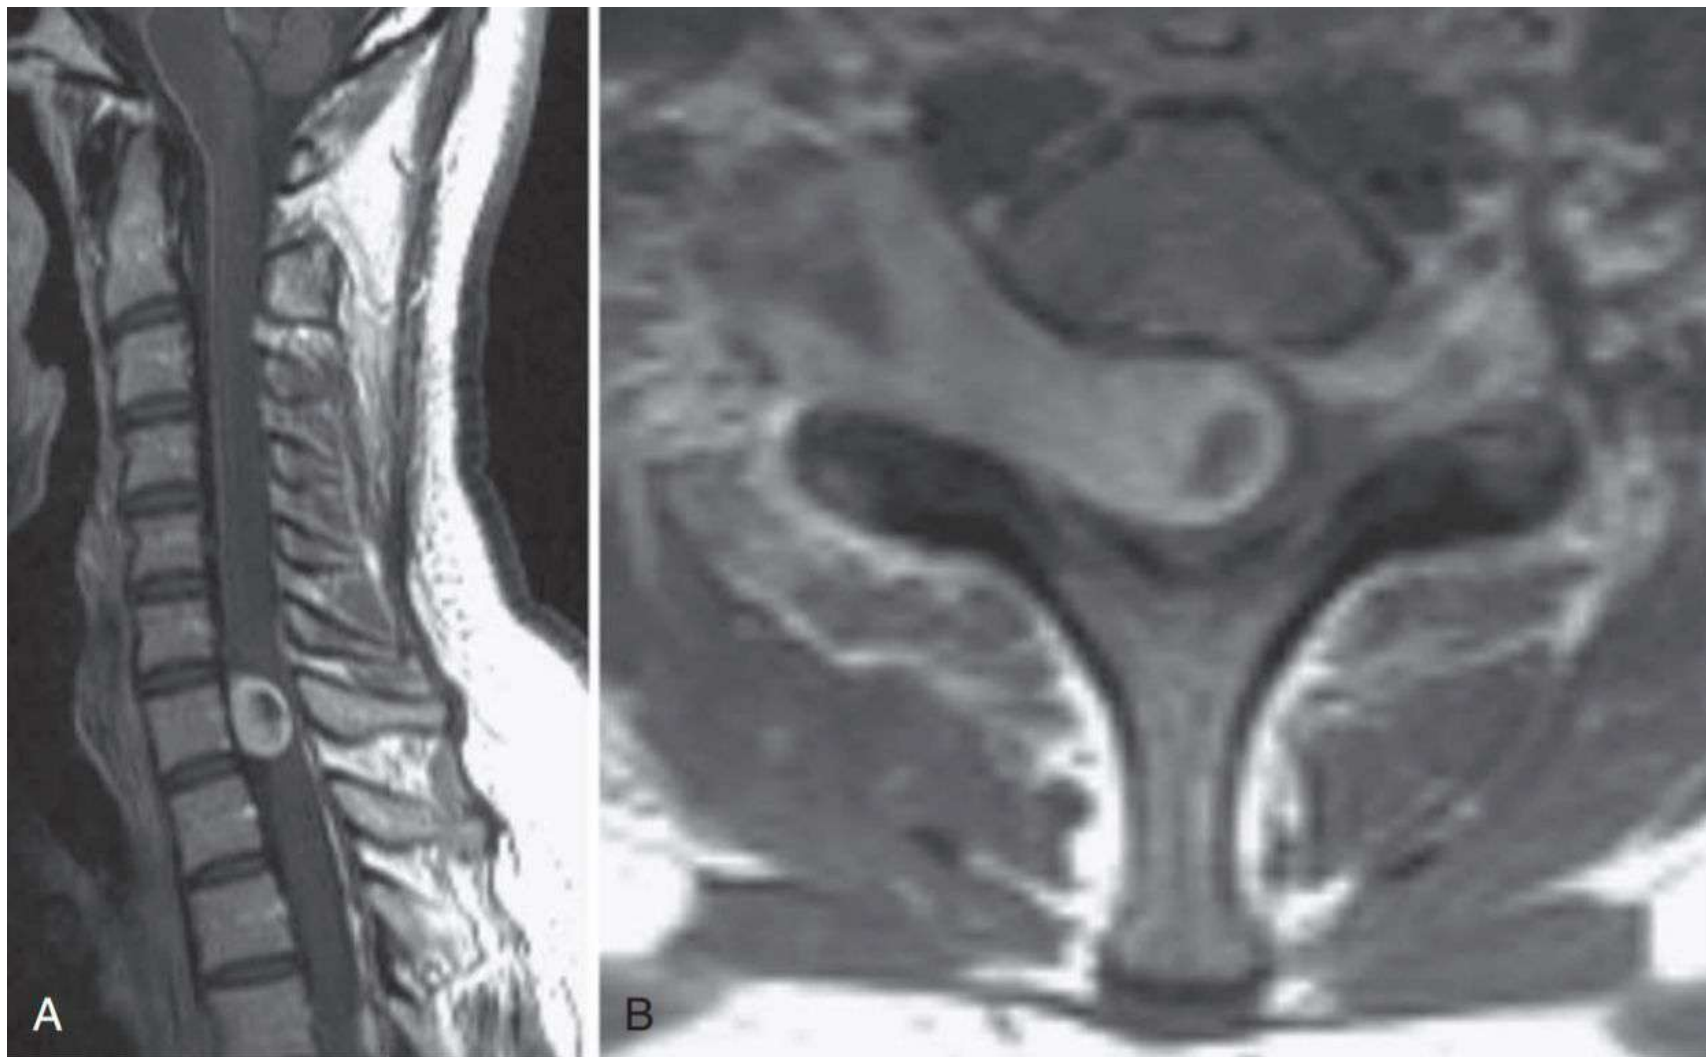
(A) Sagittal T1-weighted gadolinium-enhanced magnetic resonance imaging (MRI) scan showing heterogeneously enhancing, well-demarcated, extradural schwannoma. (B) Axial T1-weighted gadolinium-enhanced MRI of the same cervical schwannoma showing dumbbell-shaped tumor extending through the right neural foramen.
